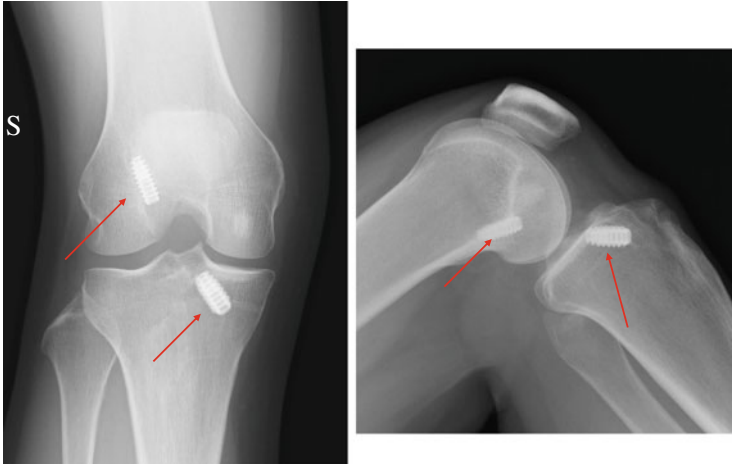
Plain lateral radiographs of Case 1 who has been suffering from instability for years after the primary ACLR. Note the interference screw for fixation (*solid arrows*)
